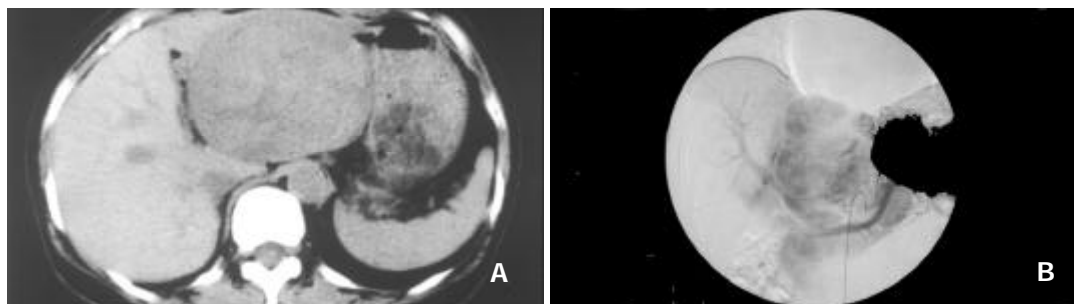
A: Computed tomography revealing a large tumor in the left lobe. B: Celiac angiography during the arterial phase, showing a large hypervascular lesion.
